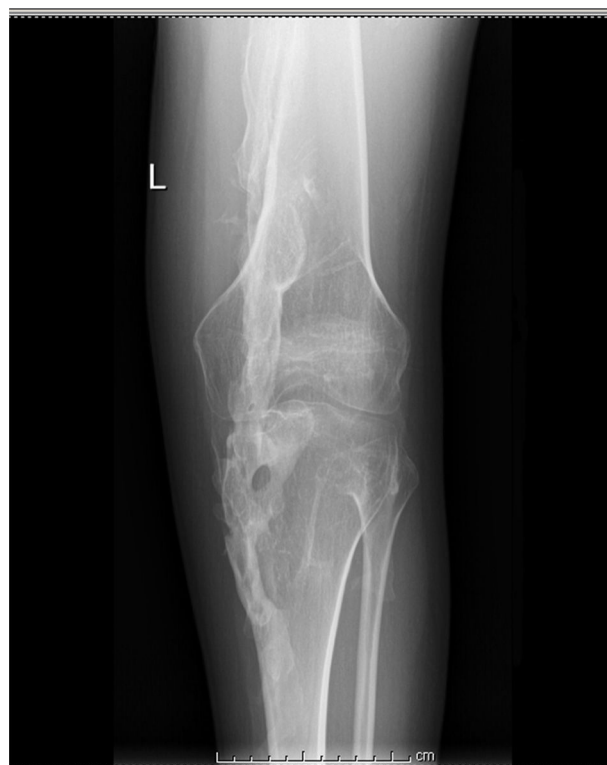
Radiograph of left knee showing ankylosis secondary to bone bridges.
